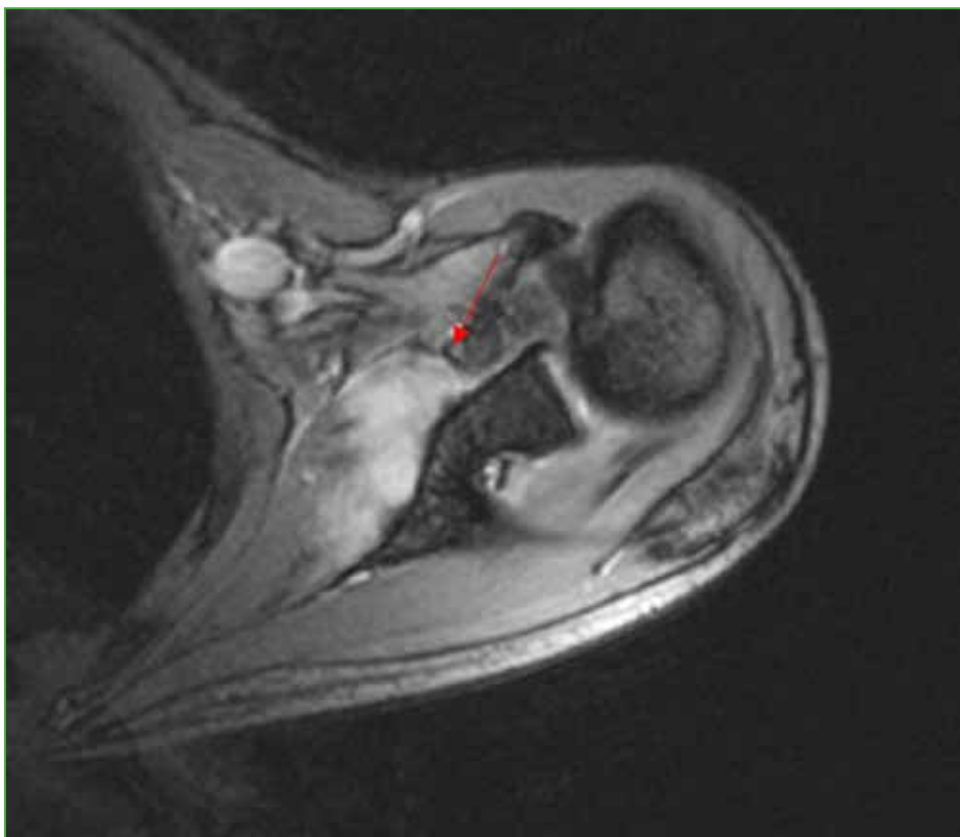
MRI of the left shoulder, axial section, STIR sequence. The red arrow indicates the subscapular tumor.
